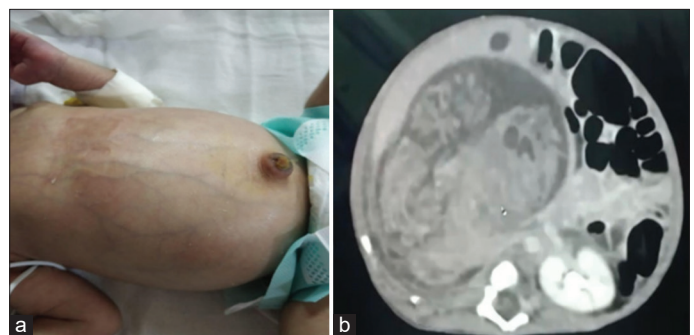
(a) Abdominal mass with dilated veins and (b) computed tomography image of the right renal mass in a 2-day-old neonate
